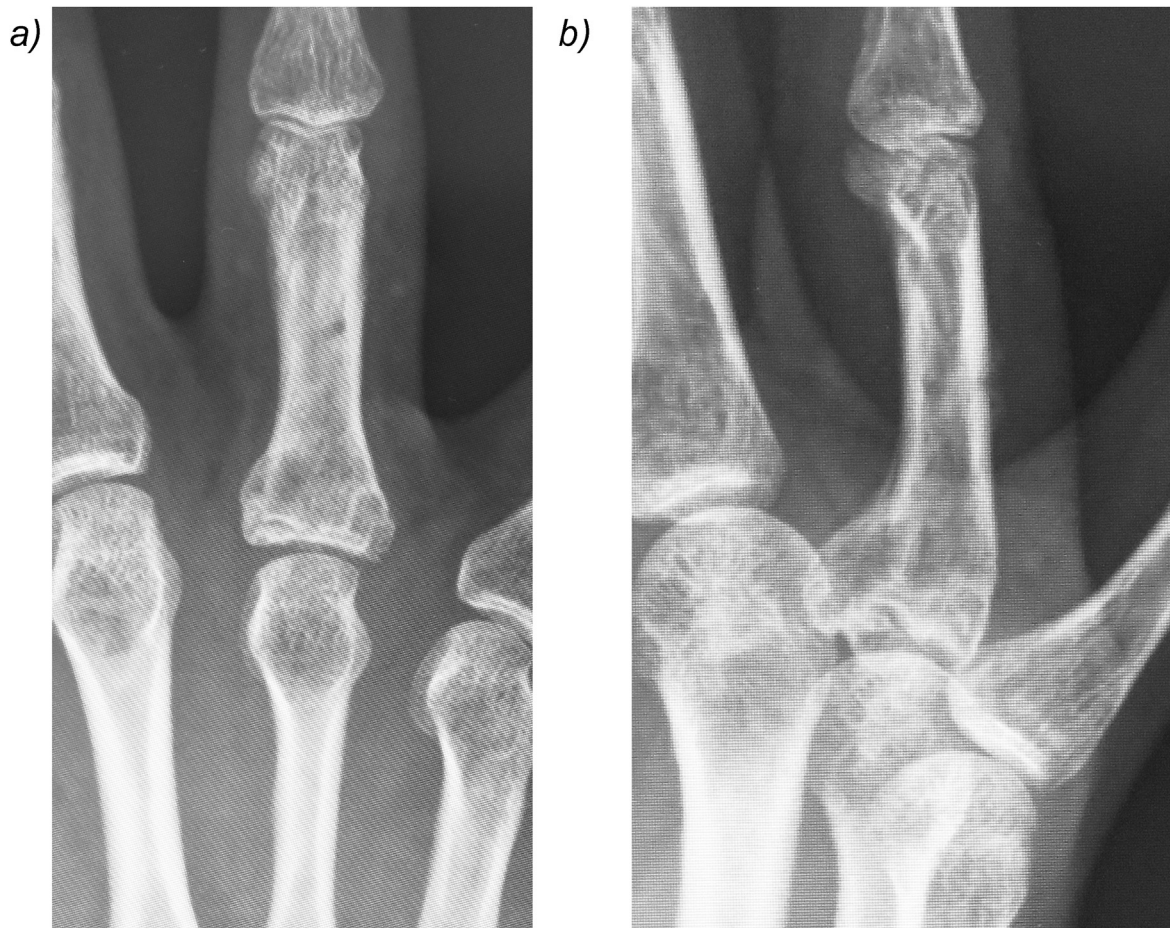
X-ray 5 months postoperatively showing the healed fracture.
